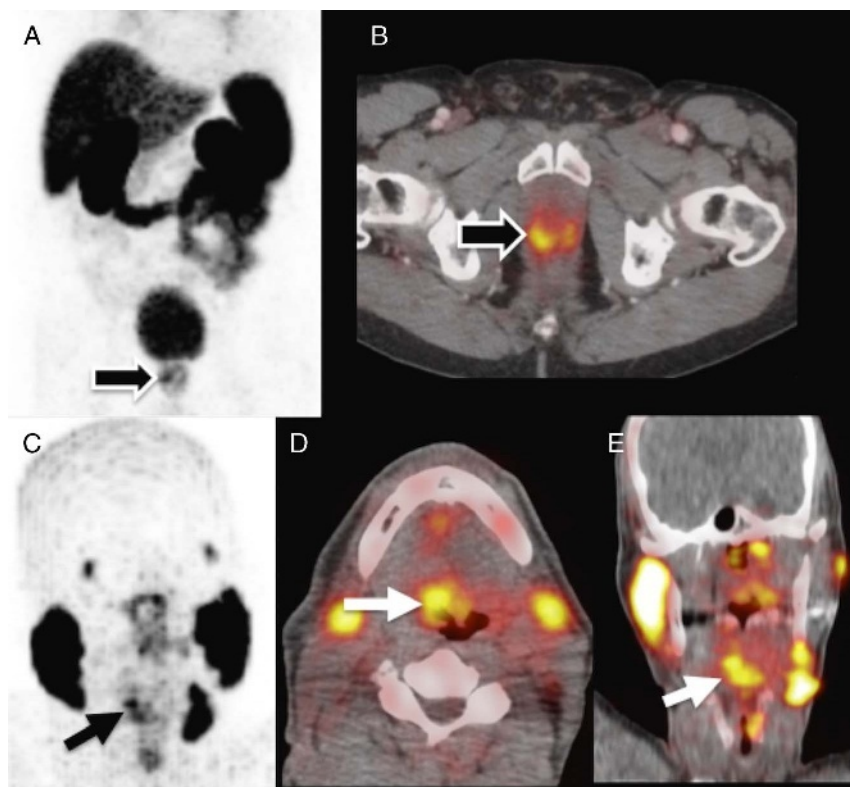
A 71-year-old man's condition was diagnosed as prostate carcinoma (Gleason 4 + 3) after a year of rising serum prostate-specific antigen (PSA) from 6.7 to 10.7 ng/mL. A ^{68}Ga -PSMA PET/CT was performed for initial staging. PET images were acquired 60 minutes after injection of 3.8 mCi (140.6 MBq). MIP PET (A) and axial fused PET/CT PET (B) images demonstrate focal radiotracer uptake (SUVmax, 6.9) in the prostate corresponding to his known primary prostate cancer (black arrow). There was no evidence of nodal or osseous PSMA avid metastatic disease. However, a PSMA avid (SUVmax, 7.9), 3.4-cm mass was incidentally found in the right oropharynx on the PET MIP images (C) that corresponded to the right base of tongue on the axial (black arrow) (D) and coronal (E) fused ^{68}Ga -PSMA PET/CT images (white arrow). Upon review of the patient's medical record, the patient's history was also significant for squamous cell carcinoma of unknown primary involving right-sided cervical lymph nodes found after right neck dissection and submandibulectomy 8 years before presentation at our institution.
